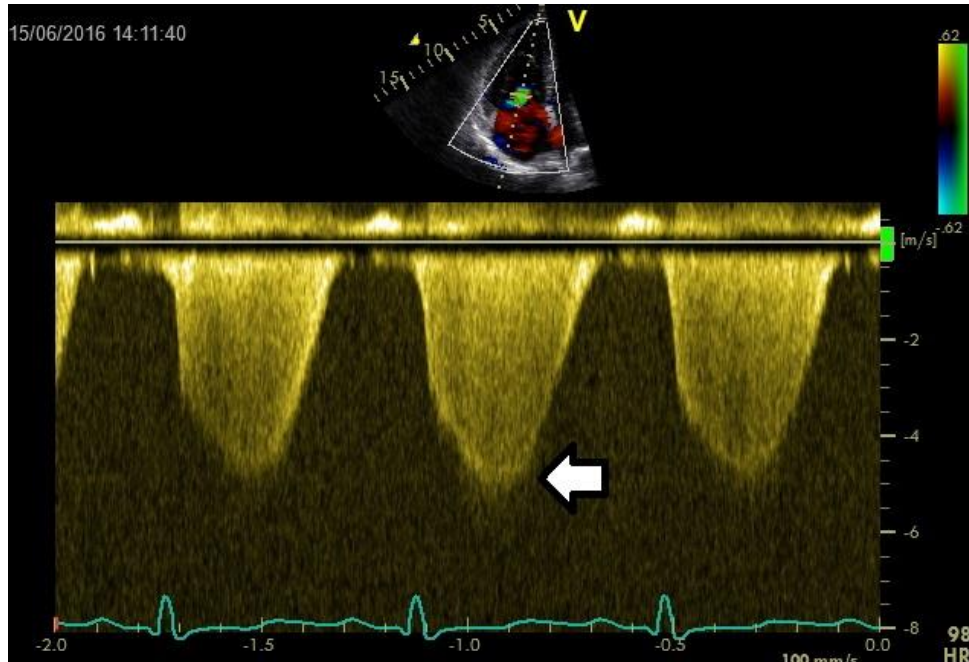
Continuous Doppler measurement of tricuspid regurgitant jet in systole. Arrow marking velocity in meter/second.
